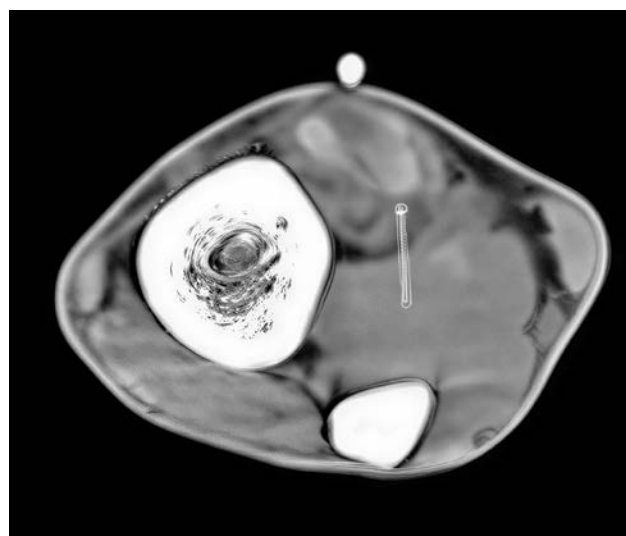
Axial CT image demonstrates an extra-articular TSGCT presenting as a soft-tissue mass with areas of increased attenuation (arrow), in keeping with blood degradation products.
